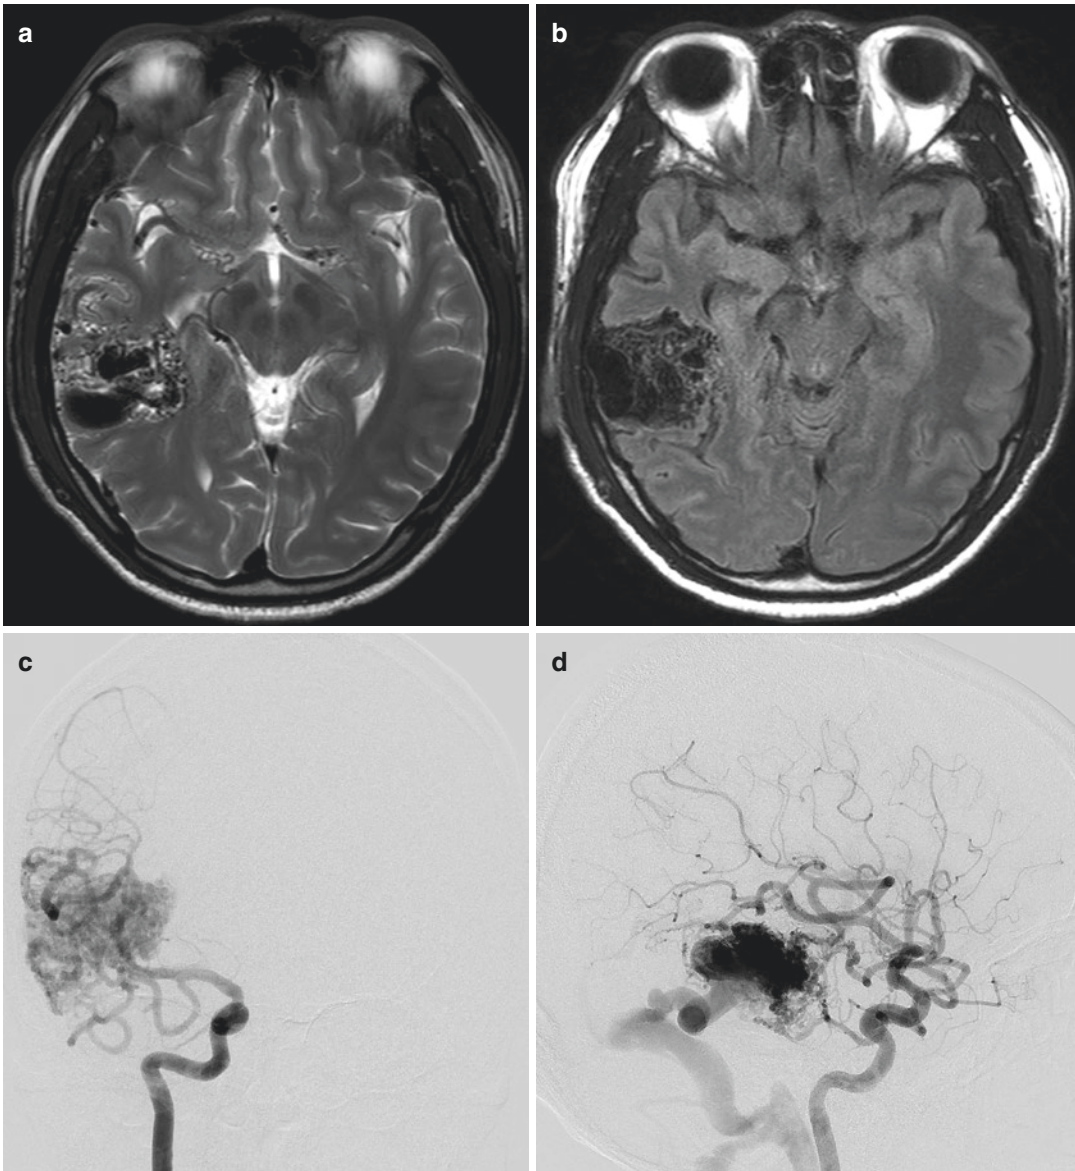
A 29-year-old male presented with a headache and dizziness. About 5 cm entangled vascular mass with signal voids in right temporal lobe (a T1 weighted MRI, b FLAIR MRI). DSA revealed engorged feeding arteries
